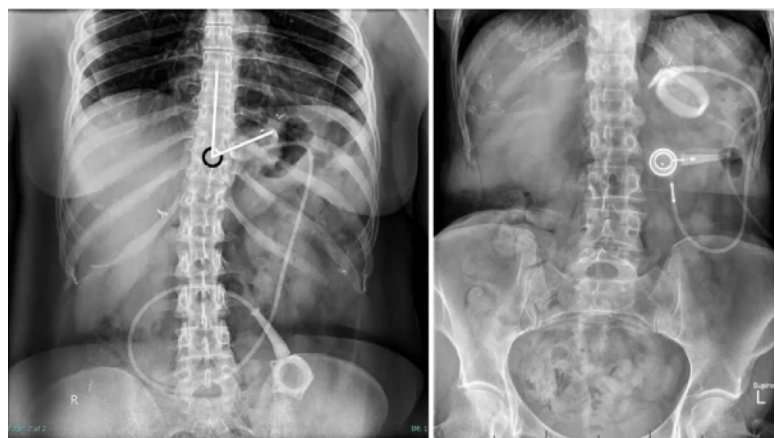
Image on the left demonstrates a phi angle of greater than 45 degrees. Image on the right demonstrates the "O Sign" which both are radiographic signs of band slippage. *Source:* Sheikh Z, Weerakkody Y, Knipe H, et al. (2025, revised).
